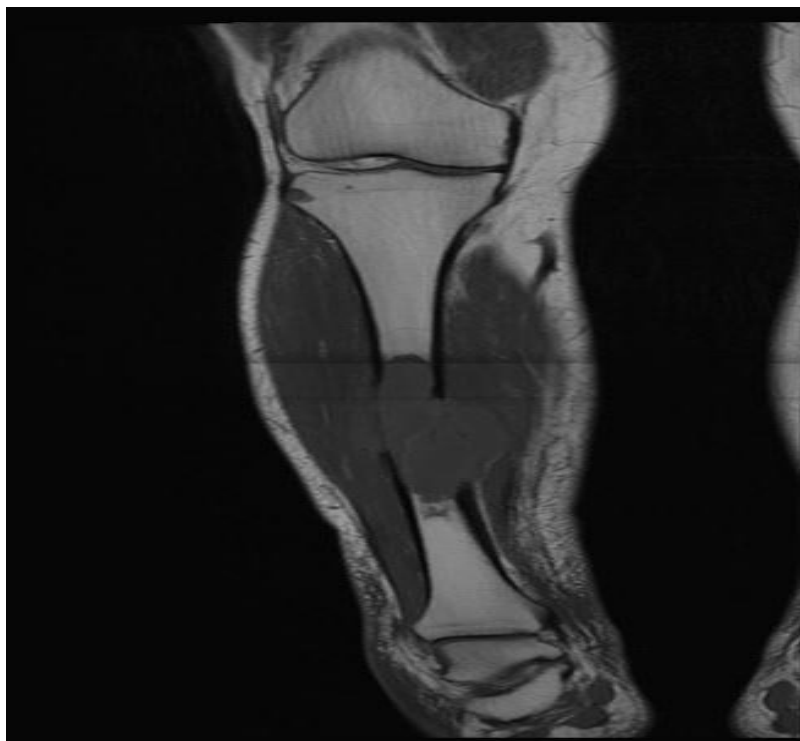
Coronal T1 weighted MRI of right lower leg. A T1 hypointense lesion is seen in the diaphysis of the tibia with cortical breakthrough and associated soft tissue mass.
